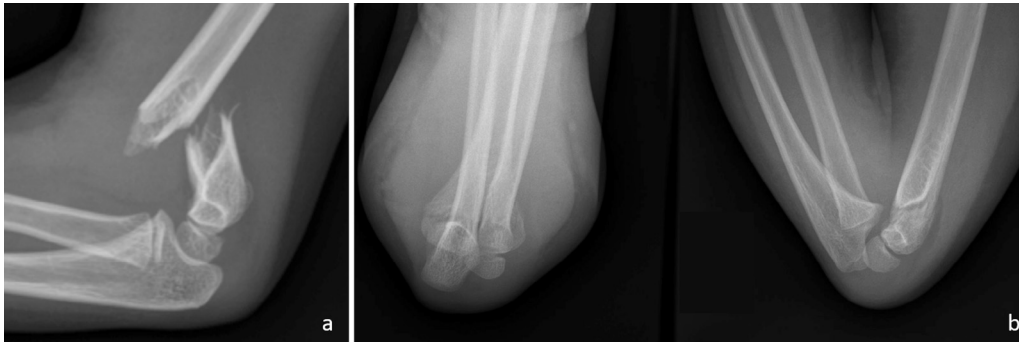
(A) Preoperative elbow radiograph, lateral view: Gartland type III supracondylar fracture of the humerus. (B) Elbow radiographs, anteroposterior and lateral views, immediately after reduction and immobilization in elbow flexion.
